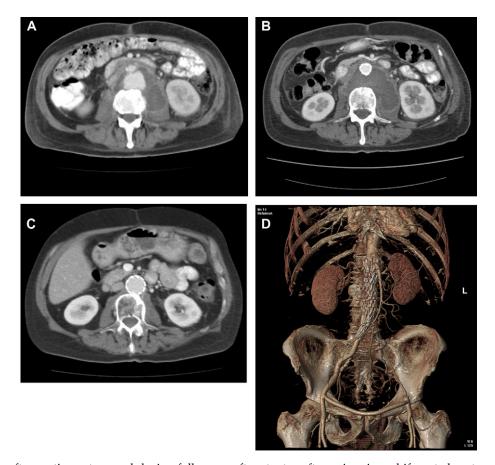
CT scans after aortic rupture and during follow-up after stent-graft repair using a bifurcated system (Zenith, TFB-3-24, COOK® Europe, Bjaerskov, Denmark). (A) Axial CT demonstrating infrarenal aortic rupture cranial to the aortic bifurcation. (B) Axial view one week after EVAR. (C) Axial view 19 months postoperatively. The aortic diameter has gradually increased up to the real diameter (24 mm) of the more than usually oversized graft. (D) Three-dimensional CT reconstruction showing the functionally aorto-monoiliac stent-graft without pathological findings and the patent cross-femoral graft 25 months after EVAR.
